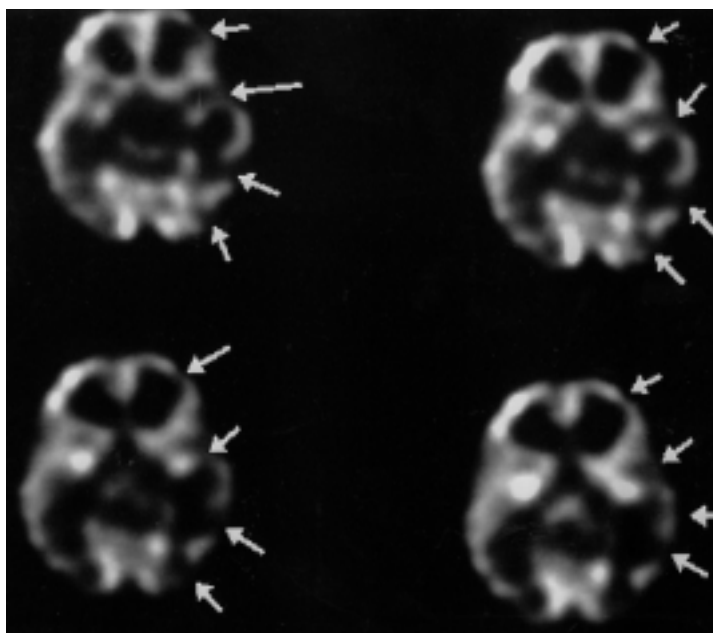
Demonstration of positive brain SPECT images in patient No. 3 of Table 1, decreased perfusion in the left hemisphere (arrows) was noted
